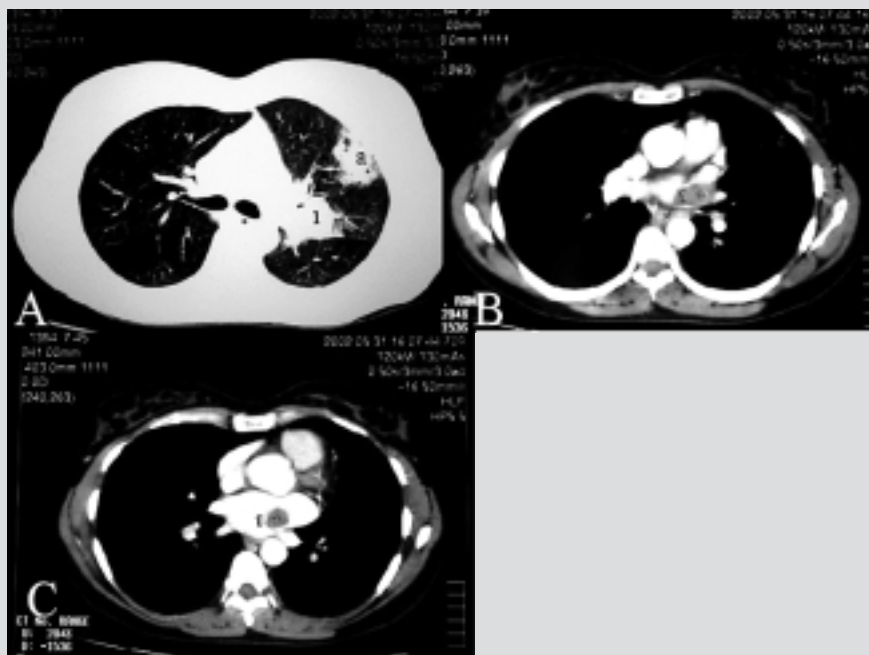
Thoracic computed tomography scan. A: pulmonary carcinoma originating from the left upper lobe bronchus; a small area of lung atelectasis (a) is also visible. B: the mass infiltrates the left upper pulmonary vein and the roof of the left atrium. C: free floating of the mass into the atrium. 1 = neoplasm.
